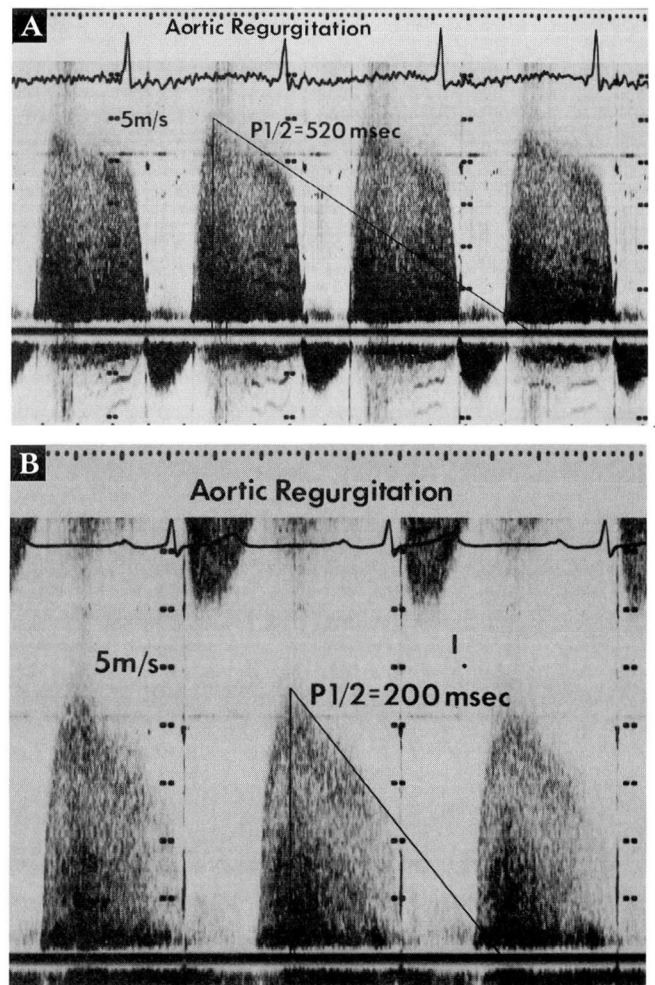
Continuous-wave Doppler echocardiography. In A, a recording of the aortic regurgitant signal in a patient with mild aortic regurgitation shows a mildly decreased pressure half-time index ($P1/2$) of 520 milliseconds. In B, a patient with severe aortic regurgitation, the pressure half-time index is markedly decreased (200 milliseconds).
